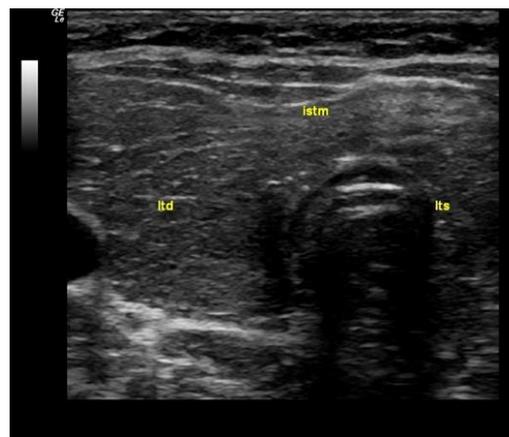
Thyroid ultrasound revealing enlarged thyroid with inhomogeneous structure, echogenic septum within the gland, normal vascularisation.
